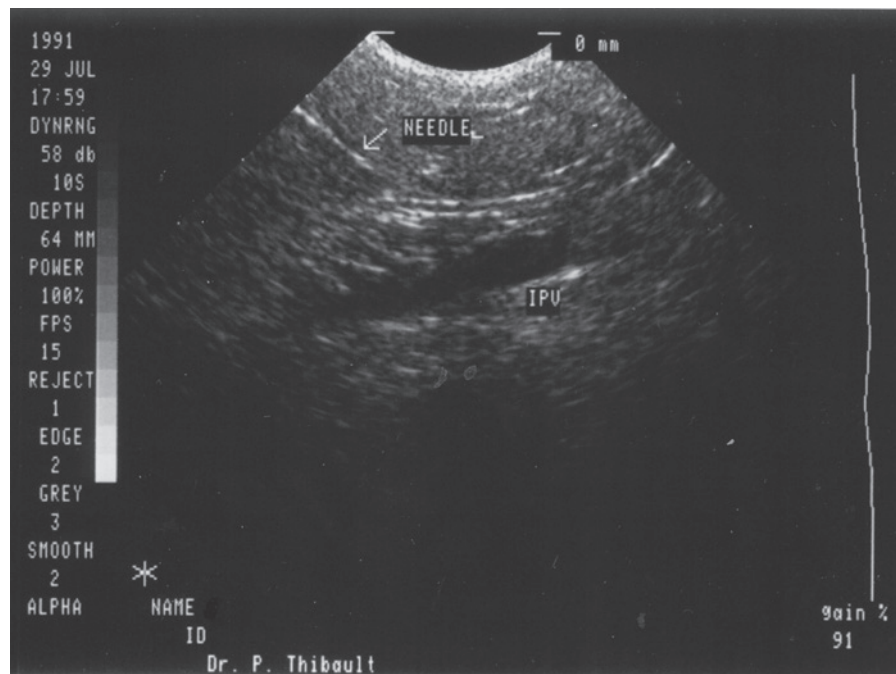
B-mode ultrasound image of needle angling toward target vein (IPV). The angle of insertion is determined by measuring the depth of proposed injection site on the ultrasound image prior to needle insertion. (From Thibault PK, Lewis WA. *J Dermatol Surg Oncol.* 1992; 18: 895–900.)
